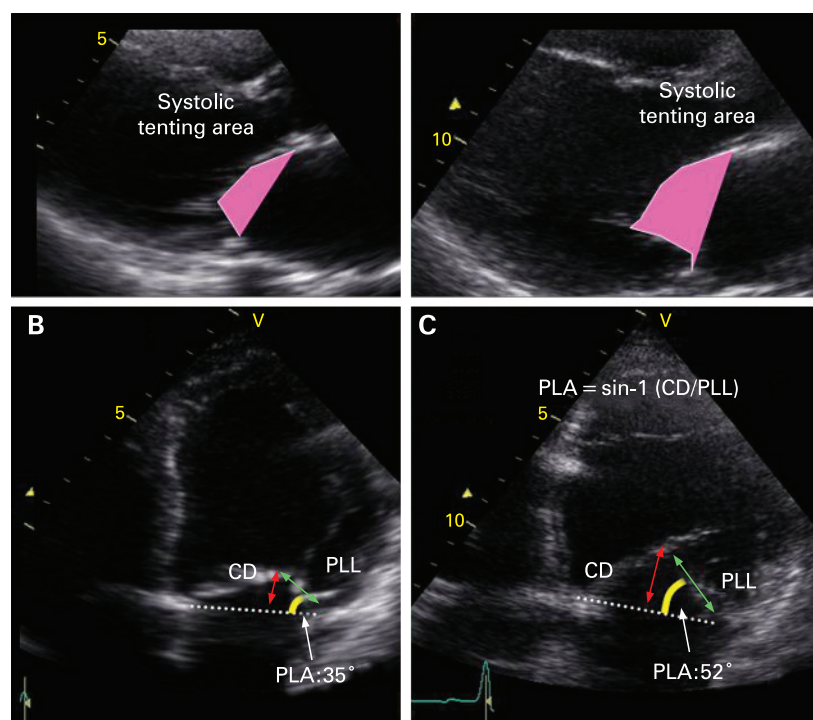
Echocardiographic assessment of mitral valve deformation. CD, coaptation distance (red arrow); PLA, posterior leaflet angle; PLL, posterior leaflet length (green arrow).
